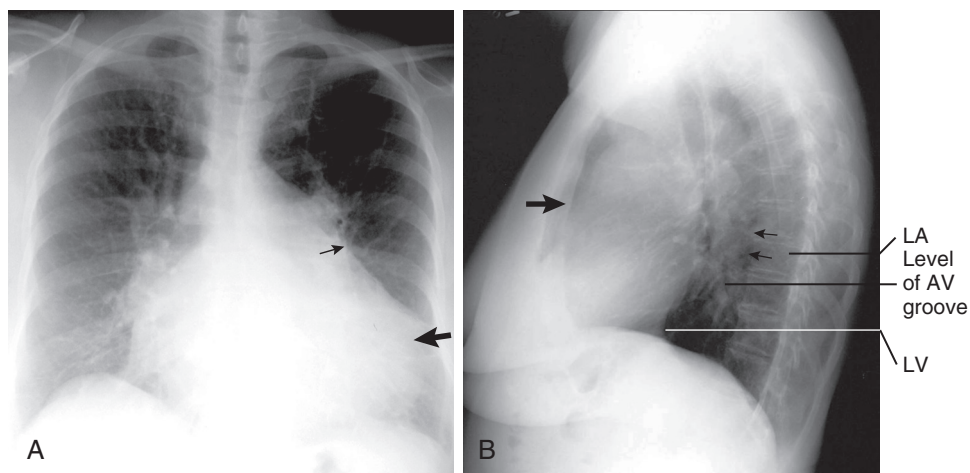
Chest radiographs of a 59-year-old woman with a history of rheumatic heart disease and mitral stenosis. A, PA view demonstrating an enlarged cardiac silhouette with suggestion of a double density seen through the heart (LA enlargement), prominent convexity of the LA appendage (small arrow), and a slightly elevated cardiac apex (large arrow) suggestive of RV (rather than LV) enlargement. There is significant elevation of pulmonary venous pressure. B, The lateral view confirms marked RV (arrow) and LA (small arrows) enlargement. Note filling in of the retrosternal airspace. AV = atrioventricular.
